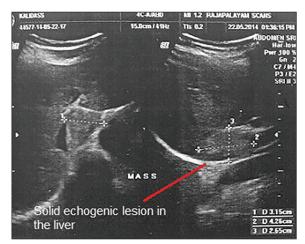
Ultrasonography shows solid echogenic lesion in the liver
